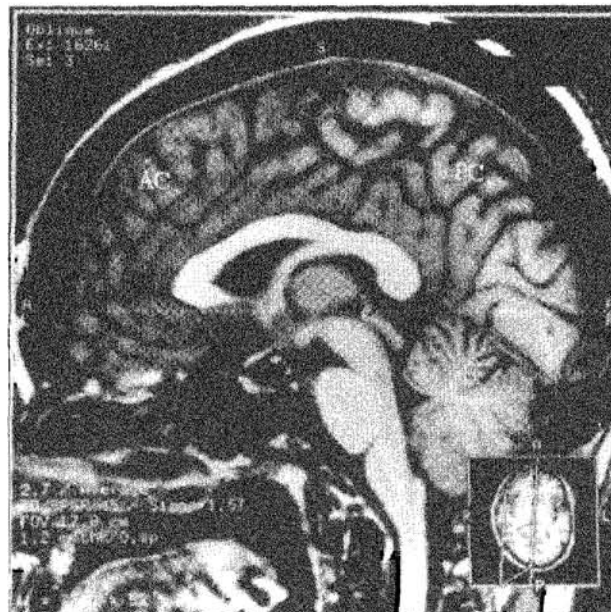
Mid-sagittal MRI image (T1-weighted) showing the anterior commissure-posterior commissure (AC-PC) line
